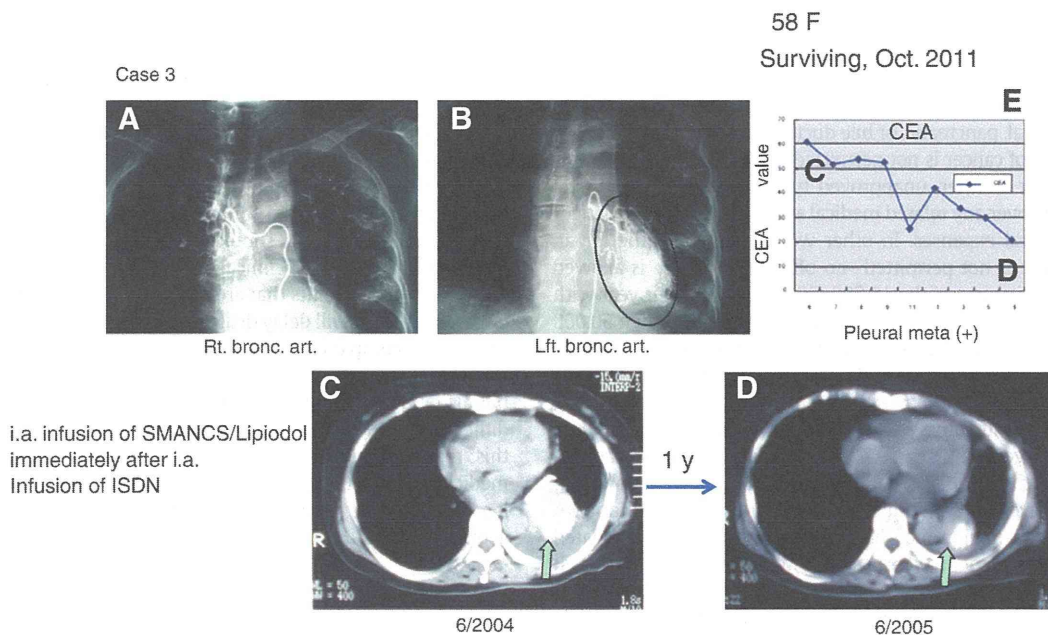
Case 3. Lung cancer (adenocarcinoma). A and B are angiograms showing infusion of contrast agent into the right bronchial artery (A) and left bronchial artery (B). These X-ray images indicate that the tumor is fed by two different arteries. (C) Initial CT scan at the start of treatment (arrow shows tumor area). (D) CT scan showing considerable tumor regression (arrow) after 1 year. SMANCS/Lipiodol, about 0.5 ml (mg), was infused into each bronchial artery immediately after infusion of a microdose of Nitrol (10–50 µg/dose). (E) One year after treatment, the tumor in the pleural cavity is considerably smaller. White areas indicate remaining drug. (E) Graph showing the decrease in the tumor marker CEA (carcinoembryonic antigen); C and D in [E] correspond to the CT scans in C and D.
